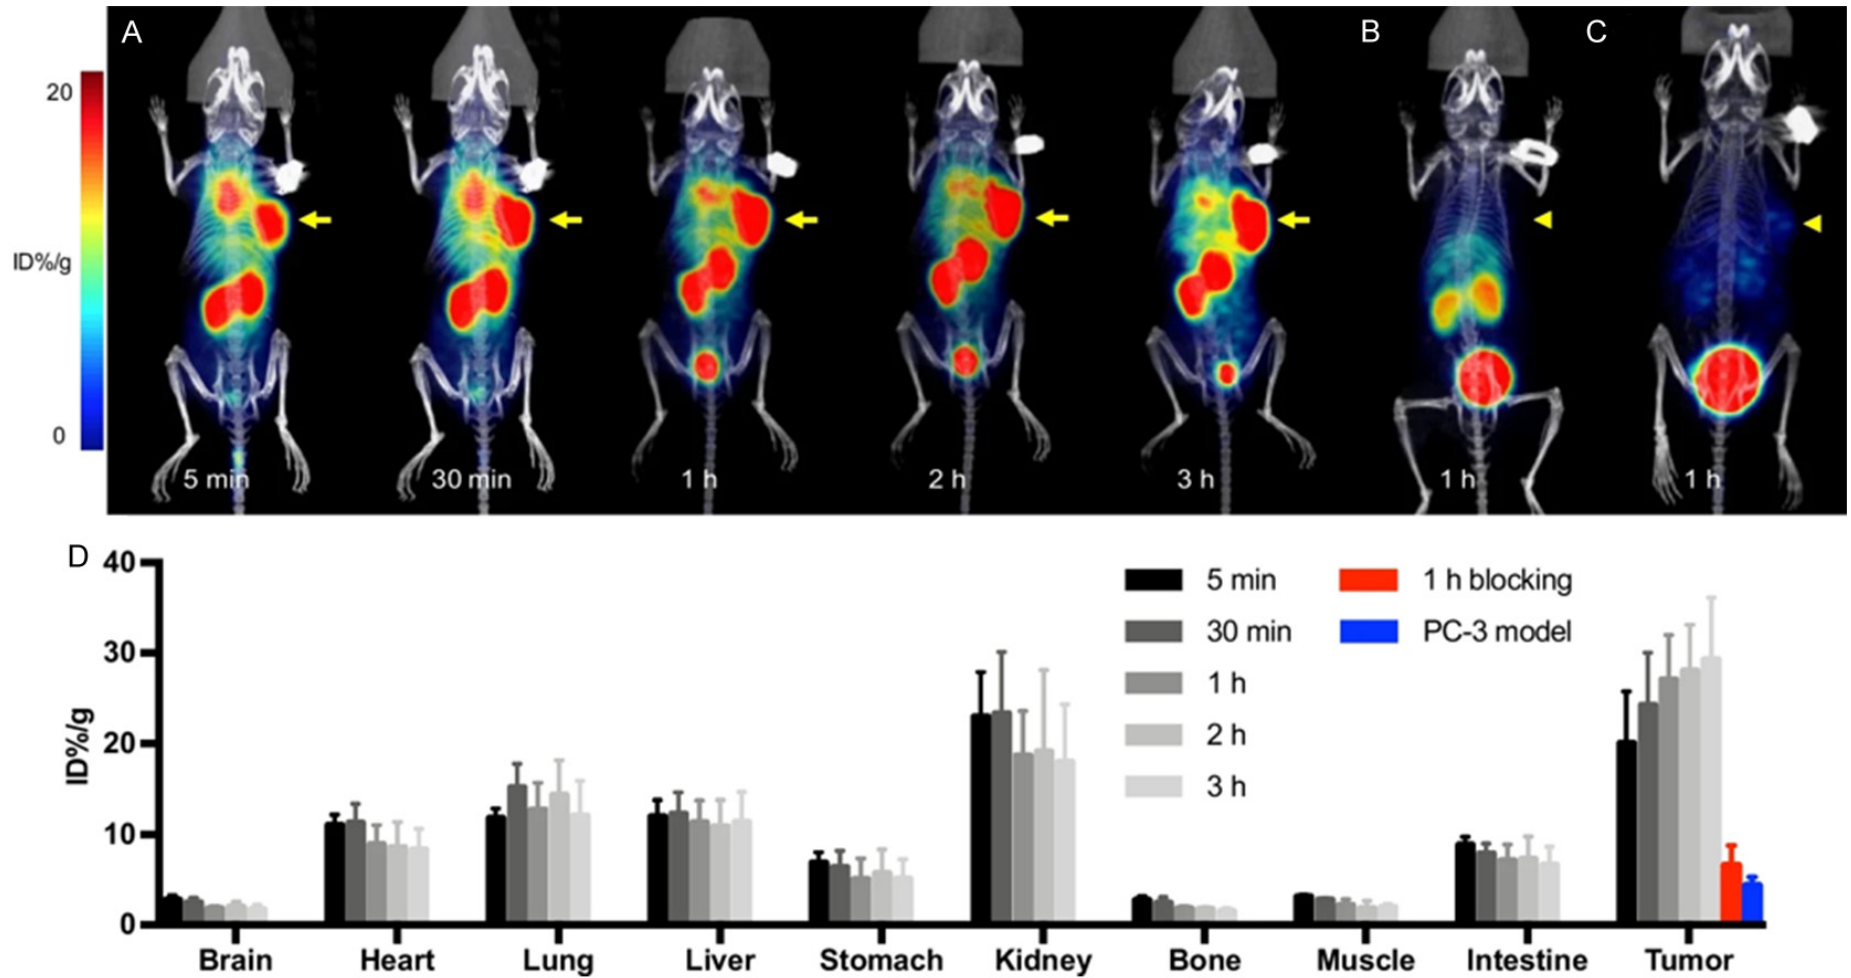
MicroPET/CT imaging shows the distribution of $[^{68}\text{Ga}]\text{Ga-NY104}$ in xenograft tumor models. A. CAIX-positive OS-RC-2; B. CAIX-negative PC-3; C. Blocking with NY104 in OS-RC-2 tumor; D. Detailed uptake information of tumors and normal tissues and organs. Reprinted with permission from [12]. © EJNMMI.
